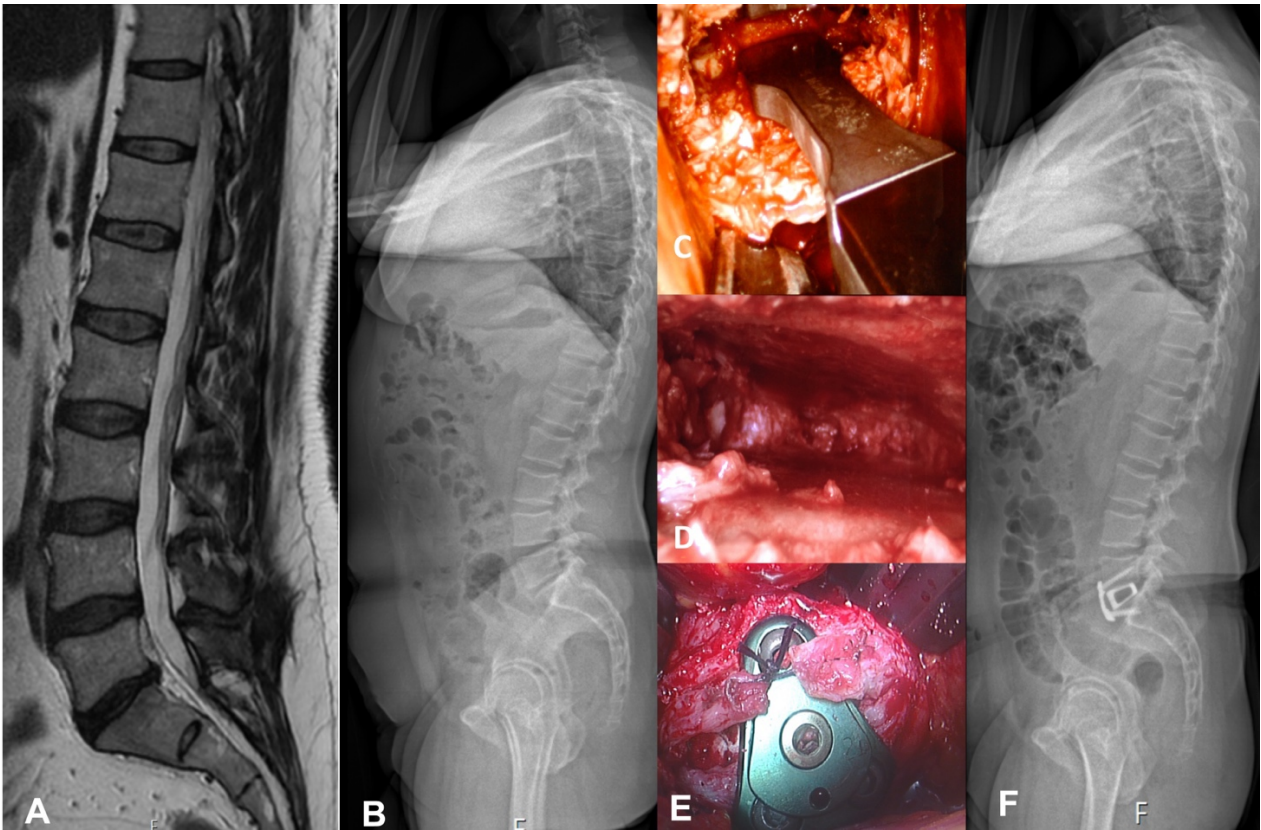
ALIF CASE EXAMPLE: A-F: Case example of M, 52, preoperative neurological status: low back pain and left sciatica with sensory impairment on L5 on the left, resistant to conservative treatment. A: T2 sagittal plane MRI showing L5-S1 Pfirrmann 4. B: Preoperative whole standing spine X-rays (EOS) showing normal sagittal and coronal balance. C-D-E: Intraoperative endoscopic view and magnification showing mobilization of the two vertebral bodies with a spreader, the posterior wall of the disc space and the two preserved anterior ligament flaps sutured together after the cage and 3 screws fixed plate implant. F: Postoperative whole standing spine X-rays (EOS) showing L5-S1 the correct positioning of the cage and L5-S1 lordosis.
